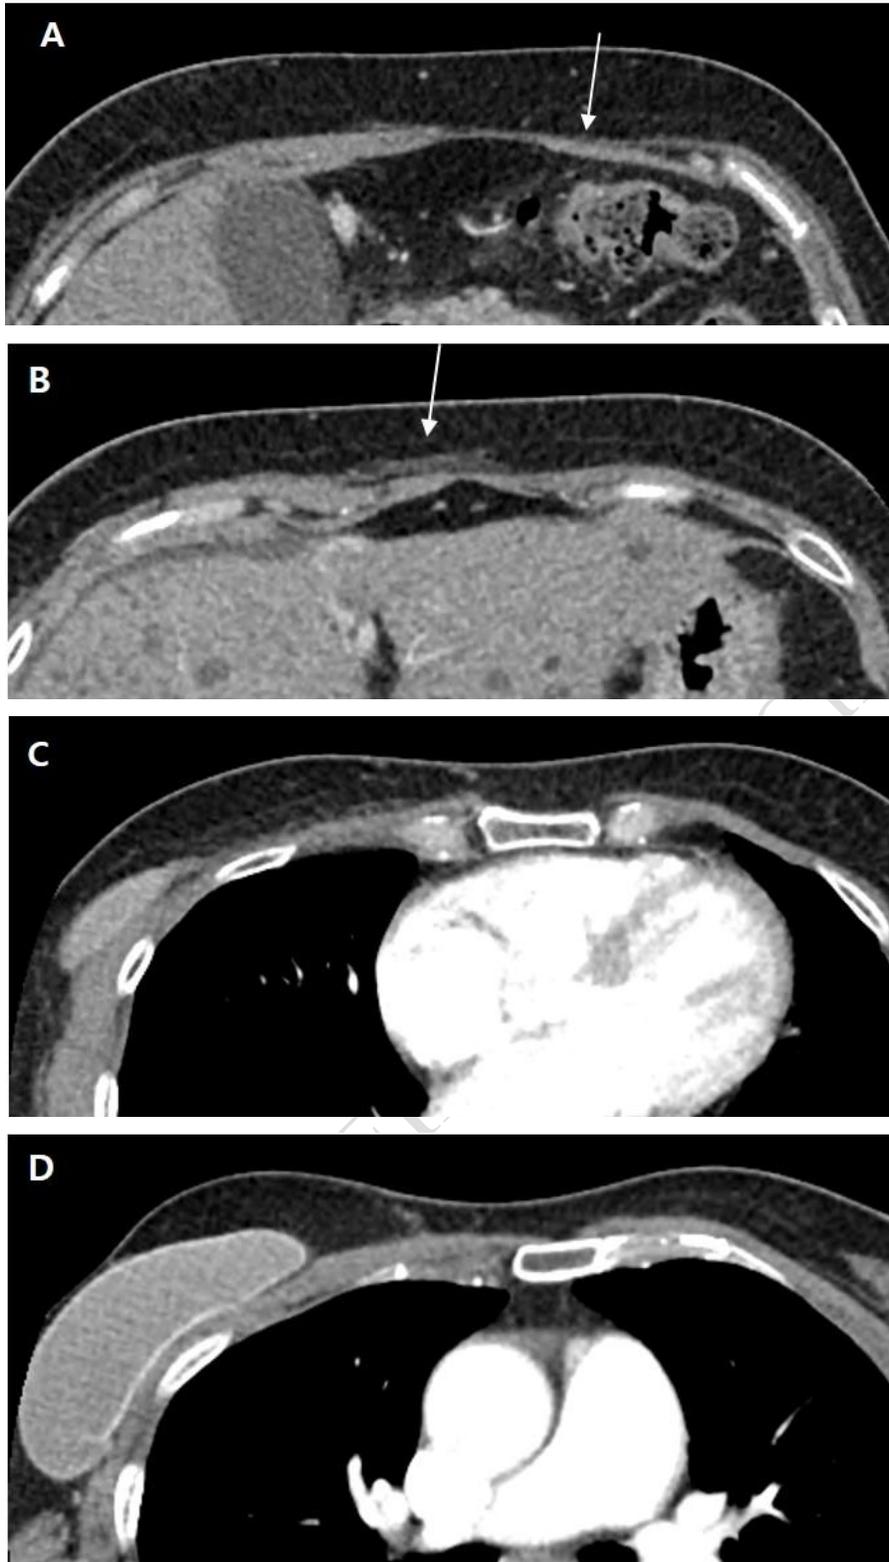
A: Chest CT acquired in a caudocranial direction demonstrating absence of the left rectus abdominis muscle (arrow), indicating its use as a donor site for the TRAM flap, B: Image showing the pedicle (arrow) connecting the abdominal donor site to the reconstructed right breast, C: Chest CT depicting the formation of the right breast mound by the transferred TRAM flap tissue, D: Additional image showing a
